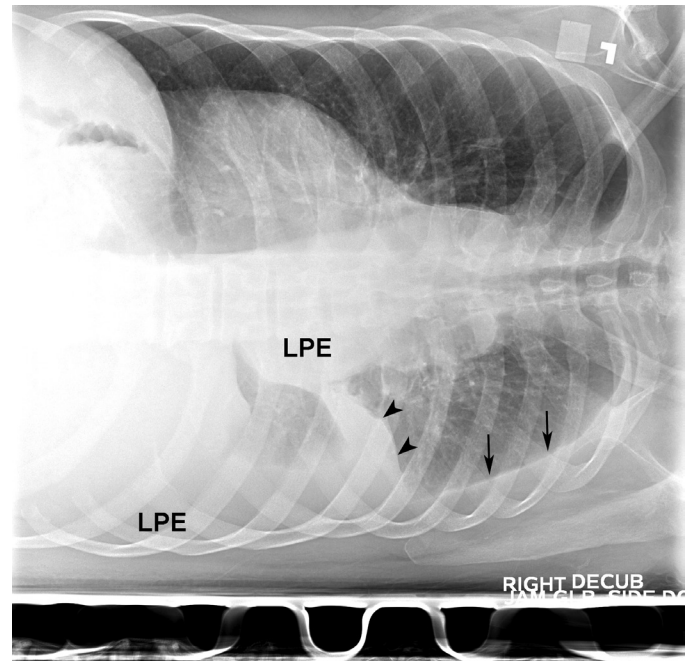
■ Right lateral decubitus chest x-ray. Right lateral decubitus film showing right pleural effusion loculated inferiorly and medially (LPE), free flowing laterally (*arrows*), and extending into the minor fissure (*arrowhead*).
